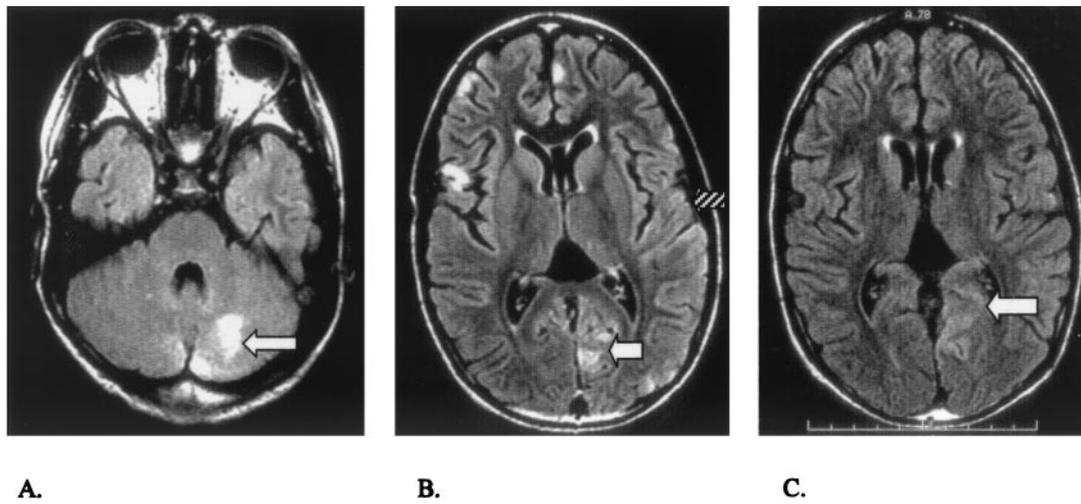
Magnetic resonance imaging (FLAIR sequences) shows brain lesions at various times in the course of the patient's hospitalization. A, Two weeks after seizure onset, scan shows hyperintense lesion in the cerebellar gray matter at a time when the child remained conscious and interactive but still had nearly constant right hand and face seizures. B, Ten days after image A, scan shows additional lesions in both cerebral hemispheres. Note particularly the left mesial occipital lesion (white arrow) and subtle, more diffuse increased signal in the left central region (hatched arrow). C, Two weeks after image B, the lesions in the cerebral hemispheres had resolved.
